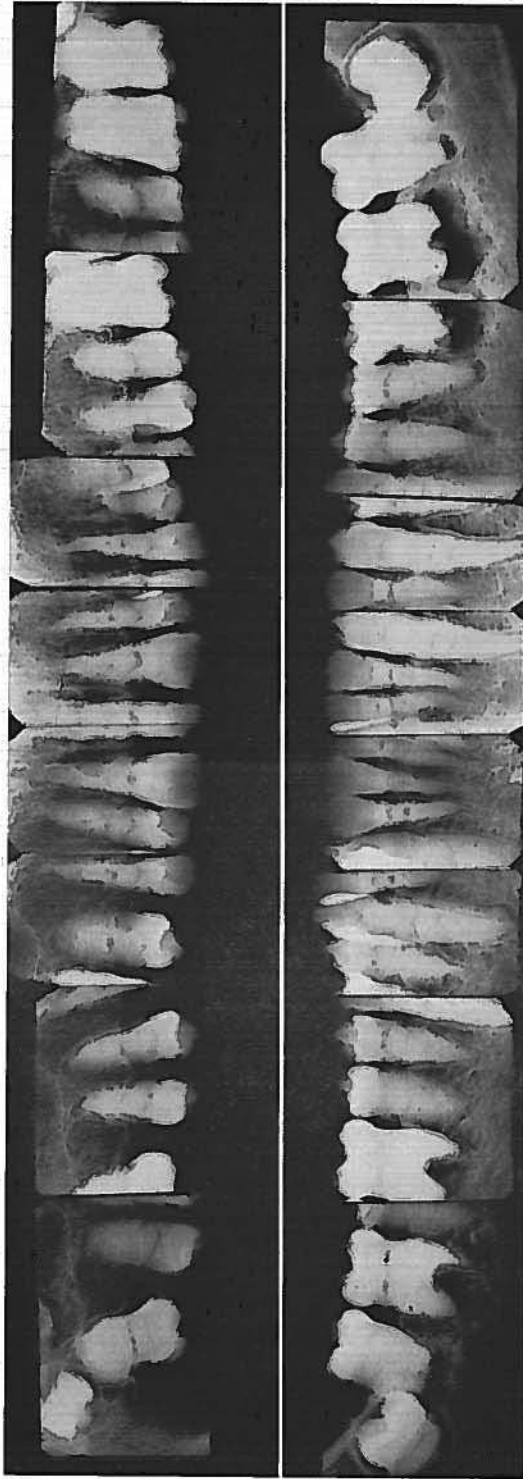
Roentgenograms of the 13-year-old son. Occluded pulp chambers with horizontal roentgenolucent lines at various levels are noticeable, with bizarre root formation, areas of apical rarefaction, and somewhat osteoporotic bone. Caries is absent.
